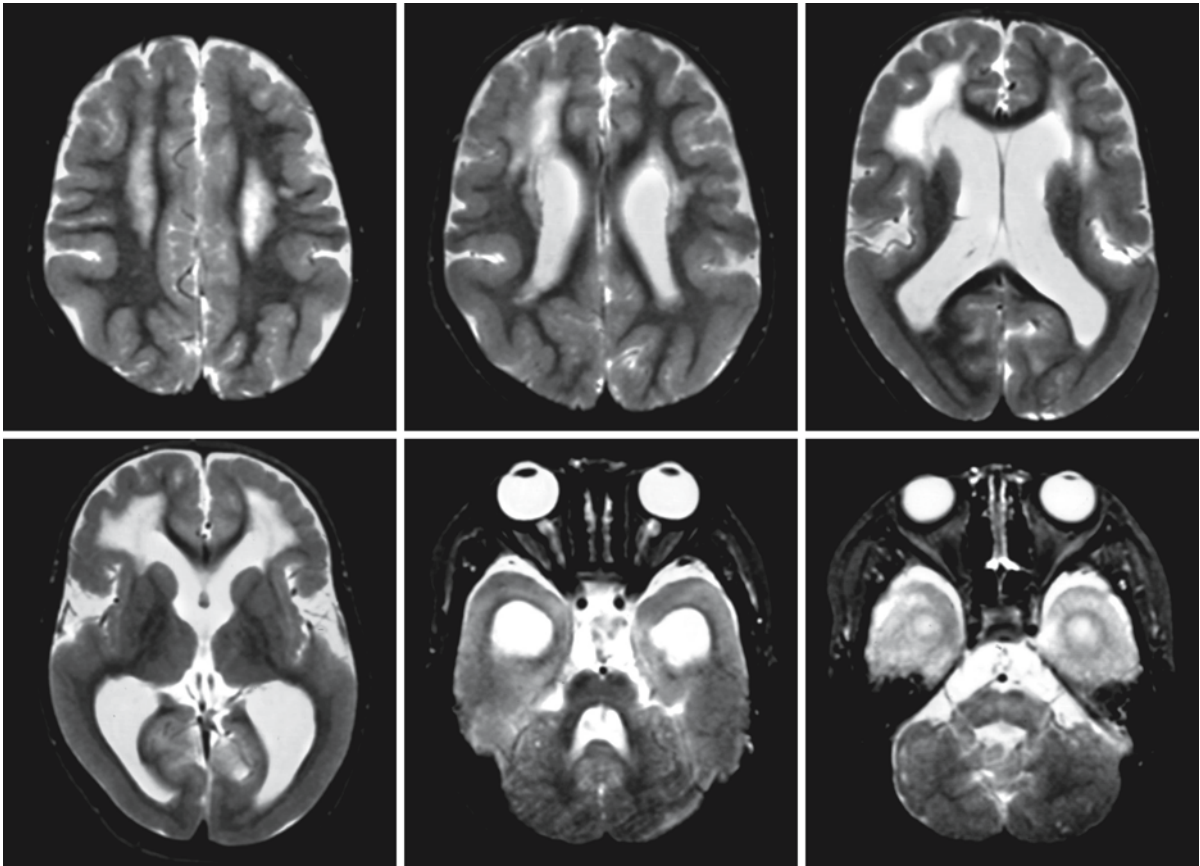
(continued). A male patient with FCMD. The first and second rows show the MRI at 5 months, the third and fourth rows contain the MRI obtained at 21 months, the fifth and sixth rows show the MRI obtained at 7 years. The frontoparietal cortex displays the characteristics of a polymicrogyric pachygyria, whereas the occipital cortex is smooth and very thick. The cerebellar cortex is also dysplastic with distortion of the normal horizontal foliae and presence of subcortical cerebellar cysts. The pons is flat. The lateral ventricles are somewhat
